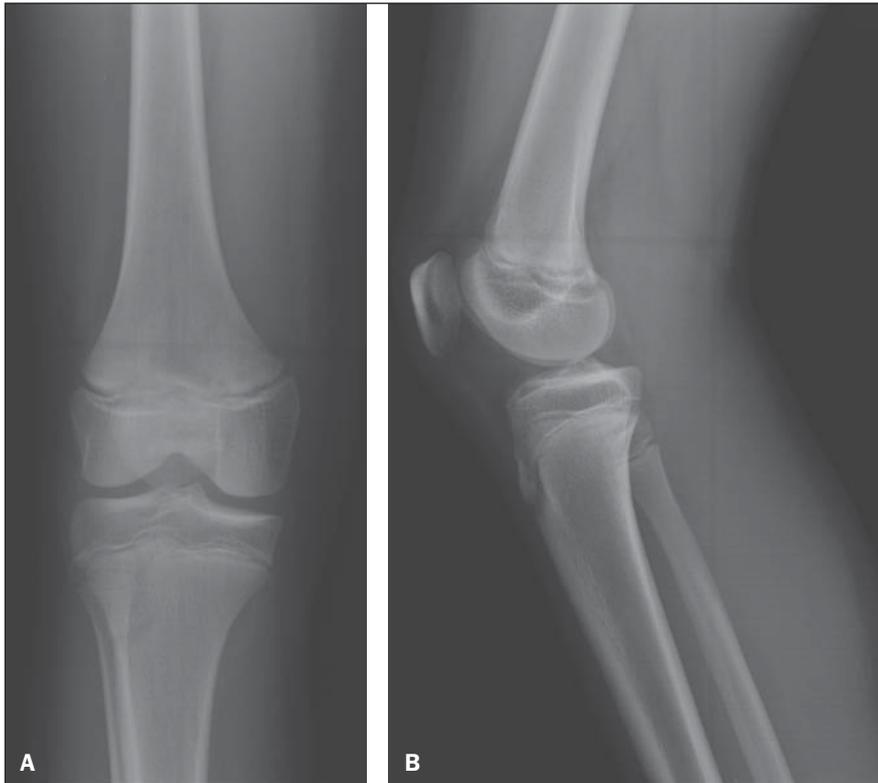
A: Anteroposterior radiograph – subtle widening of the distal femoral physis lateral compartment. B: Lateral radiograph – absence of significant changes.
